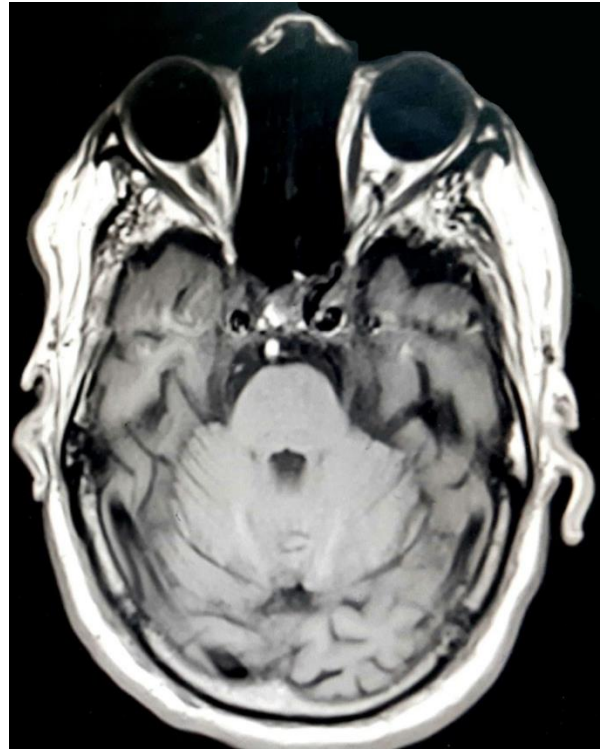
MRI T1 scan (in 2020) for the brain which shows the basilar artery crossing to the centre.
